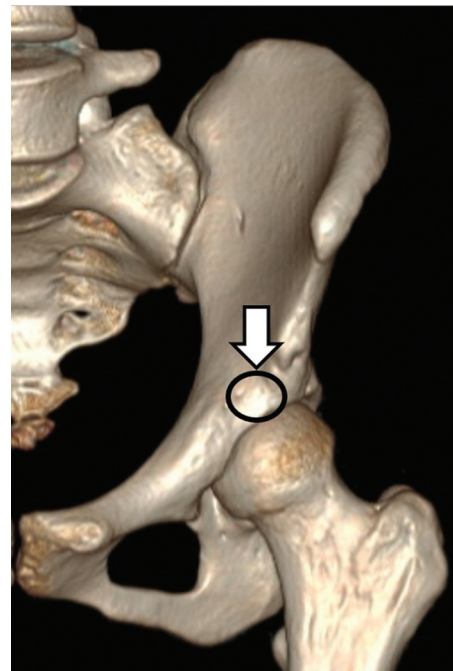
Three-dimensional reconstruction of the left hemipelvis of a patient in the supine position. The circle represents the place where, using ultrasound support, an anesthetist places the local anesthetic in the PENG block.
